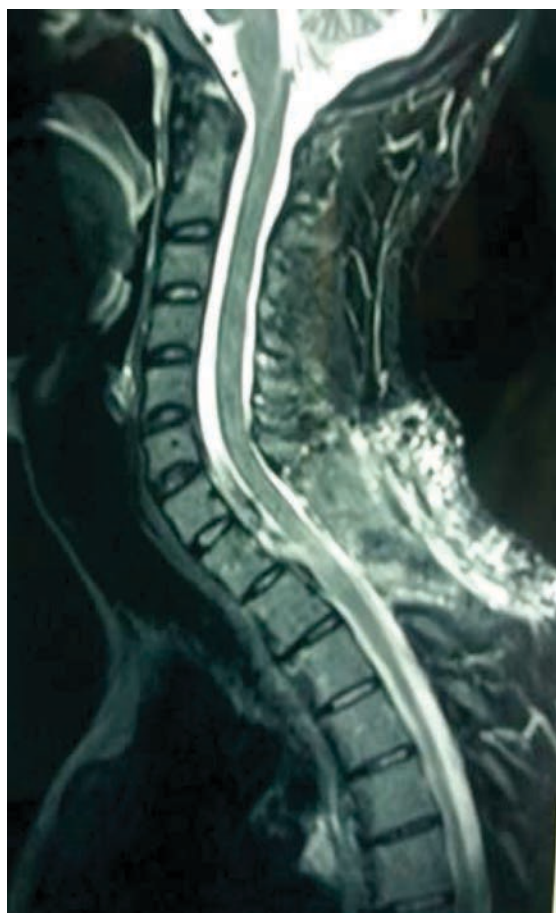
Sagittal plane MRI showing regression of tumor
